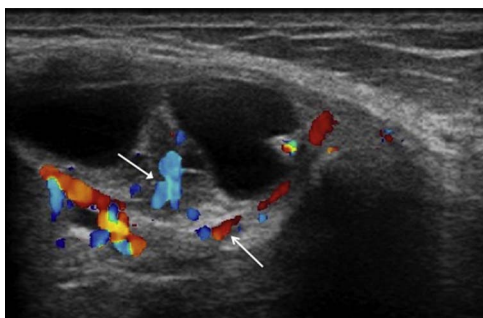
The mass, mixed fluid and solid, showed great peripheral vascularity and penetrating vessels at color Doppler (arrow).
